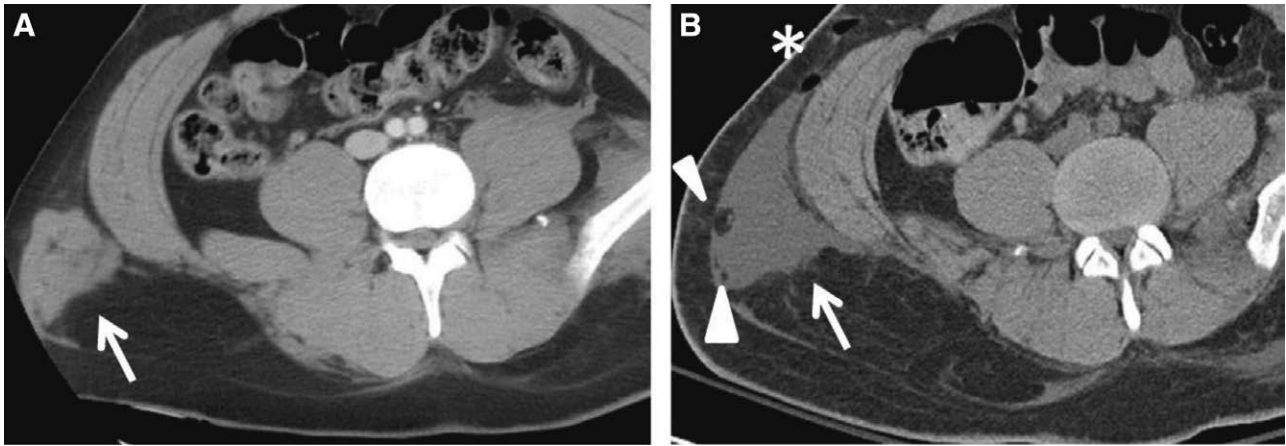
Scans of a 34-year-old woman who had been in a motor vehicle accident. A, Initial contrast-enhanced CT of the abdomen and pelvis performed within 12 h of the initial trauma demonstrates a heterogeneous hyperdense lesion of nonorganized, irregular-shaped, poorly marginated blood products in the right flank region in the deep subcutaneous tissues (arrow). B, Two days later, axial unenhanced CT demonstrates a more well-defined, partially marginated, closed internal degloving lesion (arrow) with internal fluid attenuation and small internal fat globules (arrowheads). The lesion had increased in size in the interval. Two small locules of gas are seen anteriorly, indicating suspected infection (adjacent to the asterisk in B). The lesion was later debrided and necrotizing fasciitis was found extending to the perineal region.²⁴ Reprinted with permission from Springer Nature BV.
